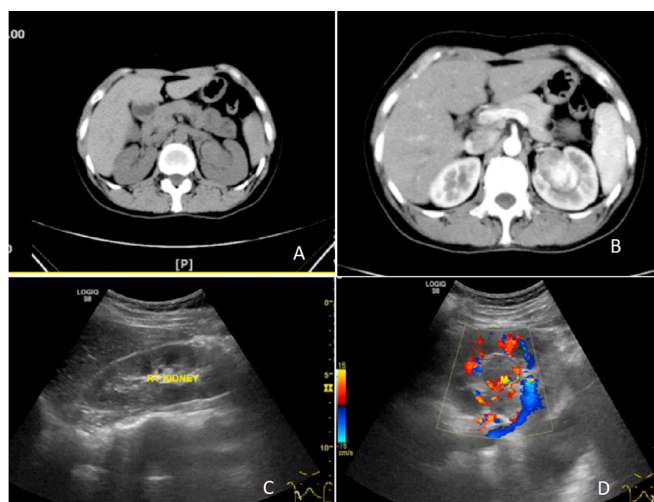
Preoperative transabdominal ultrasound and Doppler examination, preoperative CT and contrast-enhanced CT, and renal ECT examination. A:Renal CT, B:Renal contrast-enhanced CT, C:Abdominal ultrasound, and D:abdominal Doppler ultrasound.
